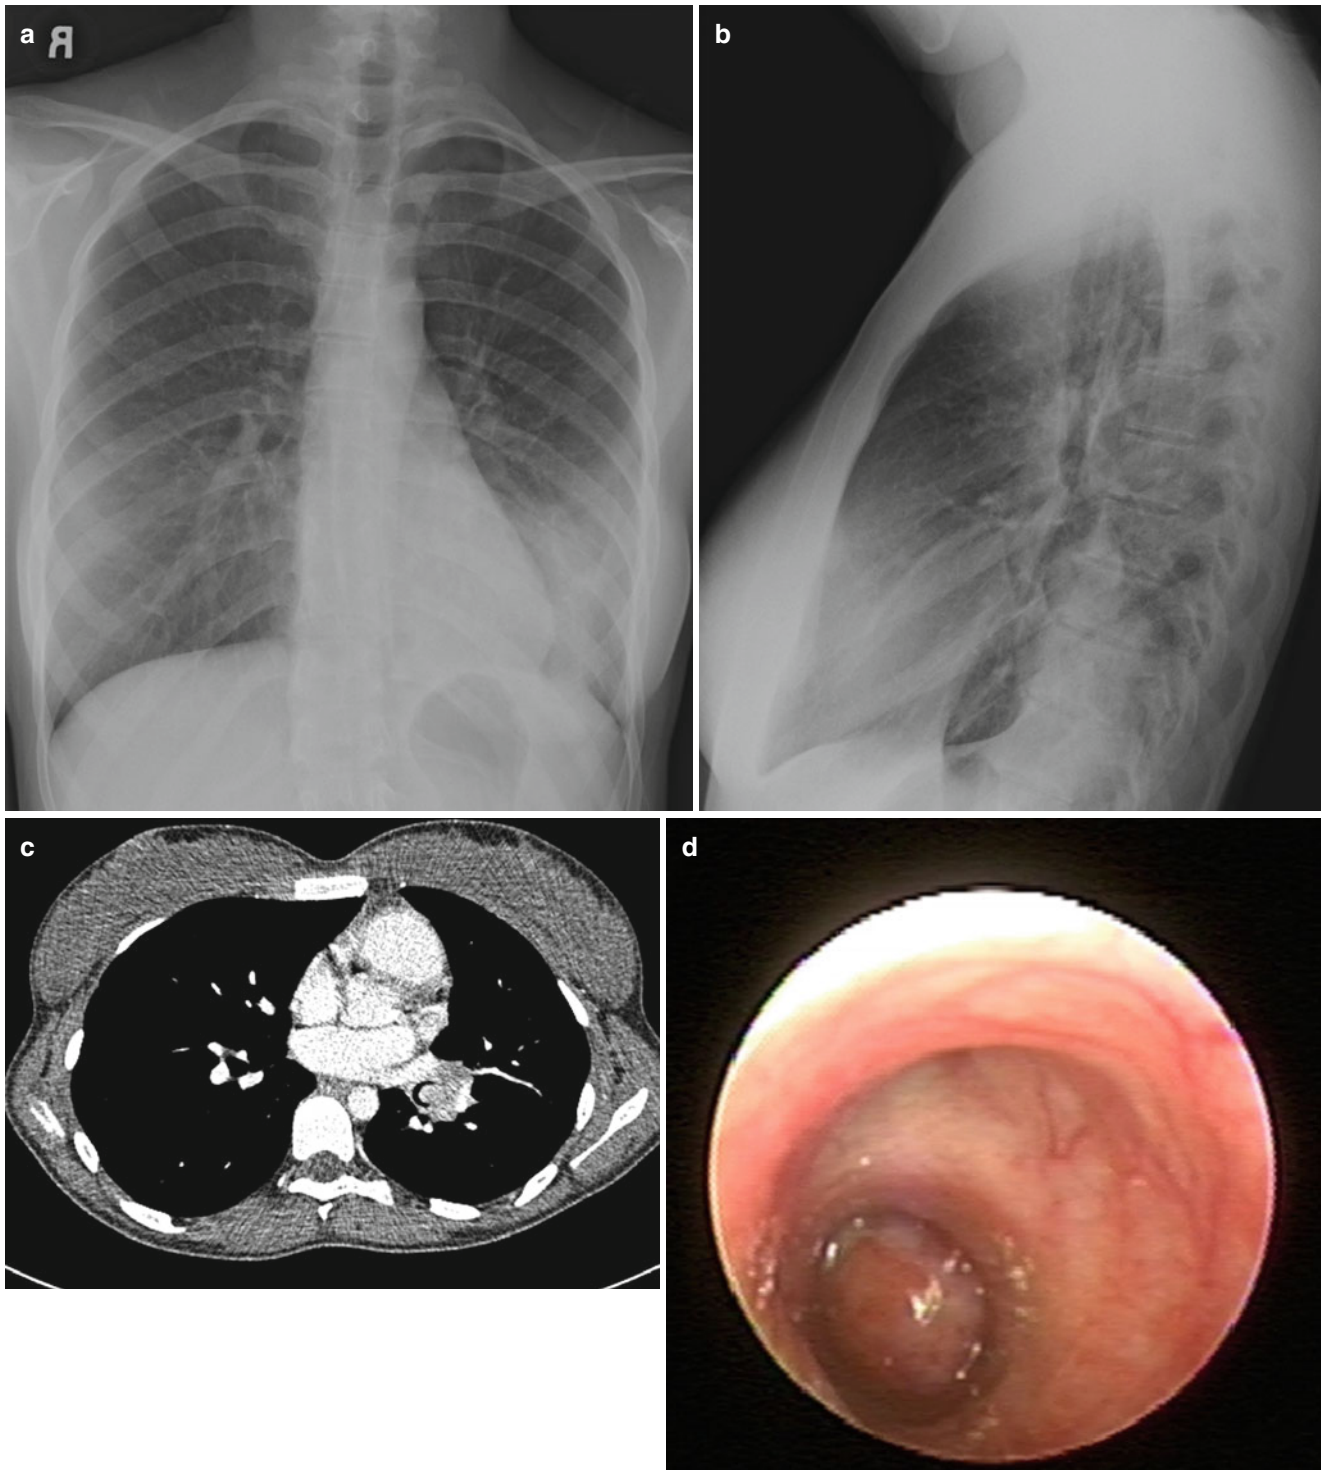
(a) This 16-year old female who presented with a pneumonia and pleural effusion which was treated with catheter drainage and antibiotics. Follow-up chest radiographs (a, b), however, continued to show collapse of the left lower lobe for over a year which led to a CT
